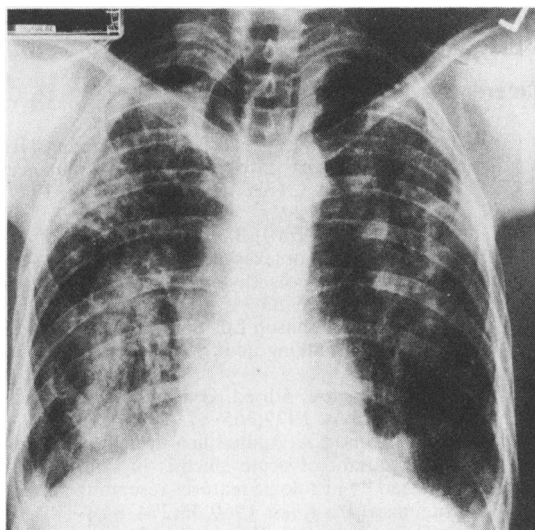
Posterioranterior chest radiograph taken in June 1980 showing conglomerate mass lesions in both lungs and loss of volume in the right upper lobe with tracheal distortion, blunting of both costovertebral angles, and bilateral pleural thickening.
